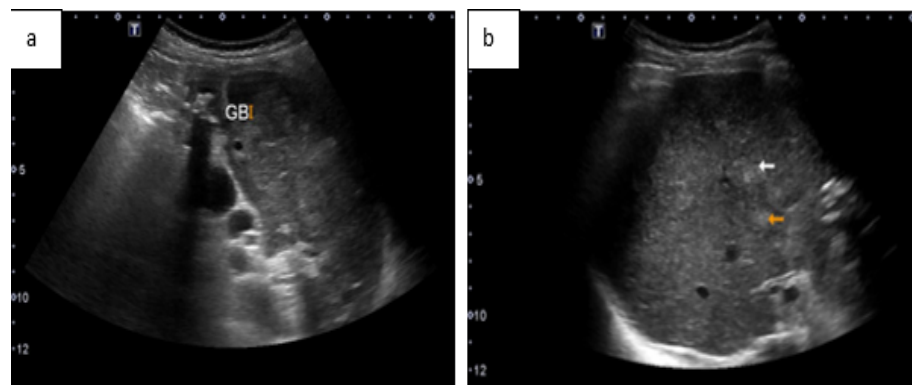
(a) Preoperative ultrasound HBS showed distended gallbladder wall with multiple stone within. No pericholecystic collection or thickened wall seen and (b) liver with coarse architecture with scattered multiple nodules. No intrahepatic duct dilatation seen.
